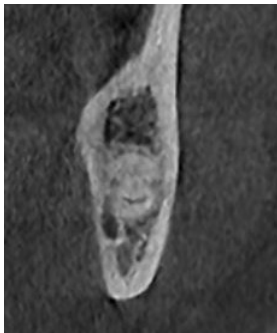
CBCT Absence of cortication
